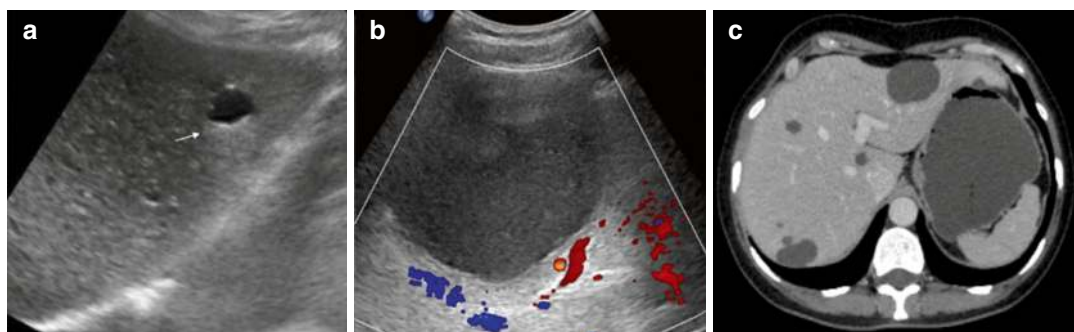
Hepatic cysts. Grayscale US image (a) shows an oval, anechoic lesion with a thin imperceptible wall and posterior acoustic enhancement (arrow), characteristic of a simple hepatic cyst. Colour Doppler US image (b) shows a unilocular hepatic cyst with fine echoes within
